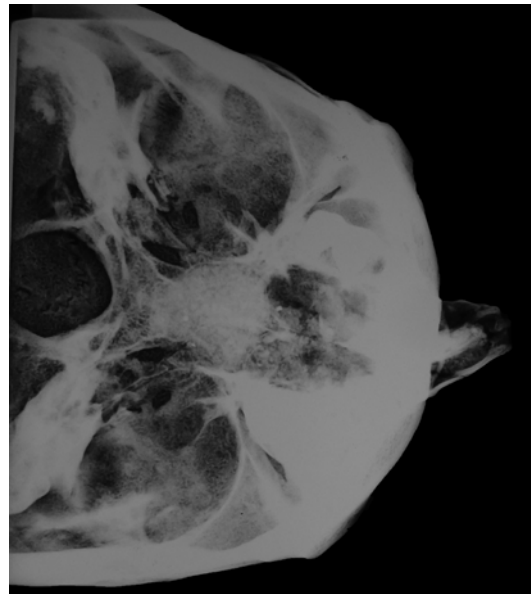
X-rays (axial view) of the nose showing its lateral deviation on the left
